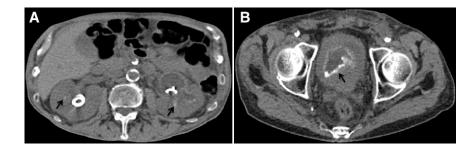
Radiologic findings of the patient. Computed tomography of the abdomen revealed bilateral ureterohydronephrosis despite double-J stents, associated with bilateral kidney stones (A) and thin opacities outlining the bladder wall (B). 81×46 mm (300×300 DPI).
